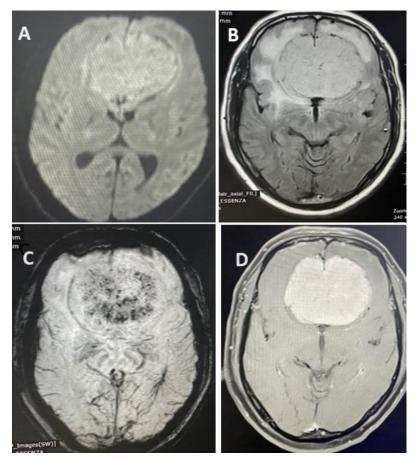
A well-defined bifrontal extra-axial space-occupying lesion invading into the floor of the anterior cranial fossa, showing restriction on DWI (A) and T2 flair sequence (B) with a sunburst appearance (A,B), blooming on SW sequence (C) with diffuse and homogenous enhancement on contrast (D) consistent with olfactory groove meningioma.
